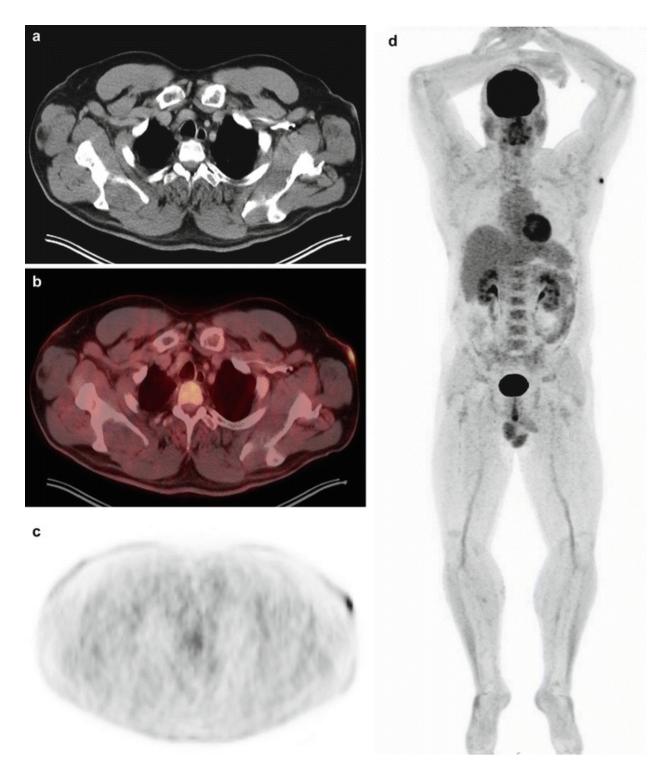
51 year old male patient suffering from malignant melanoma who underwent hybrid imaging for whole-body staging. Morphological CT (\mathbf{a}), fused PET/CT (\mathbf{b}) and PET images (\mathbf{c}) as well as a PET maximum intensity projection image (\mathbf{d}) are displayed. Intense tracer uptake in the left axillary region with cutaneous thickening was suspicious of a second malignant melanoma. Local inspection showed a local inflammation in a patient with known hidradenitis suppurativa in the axillary region
